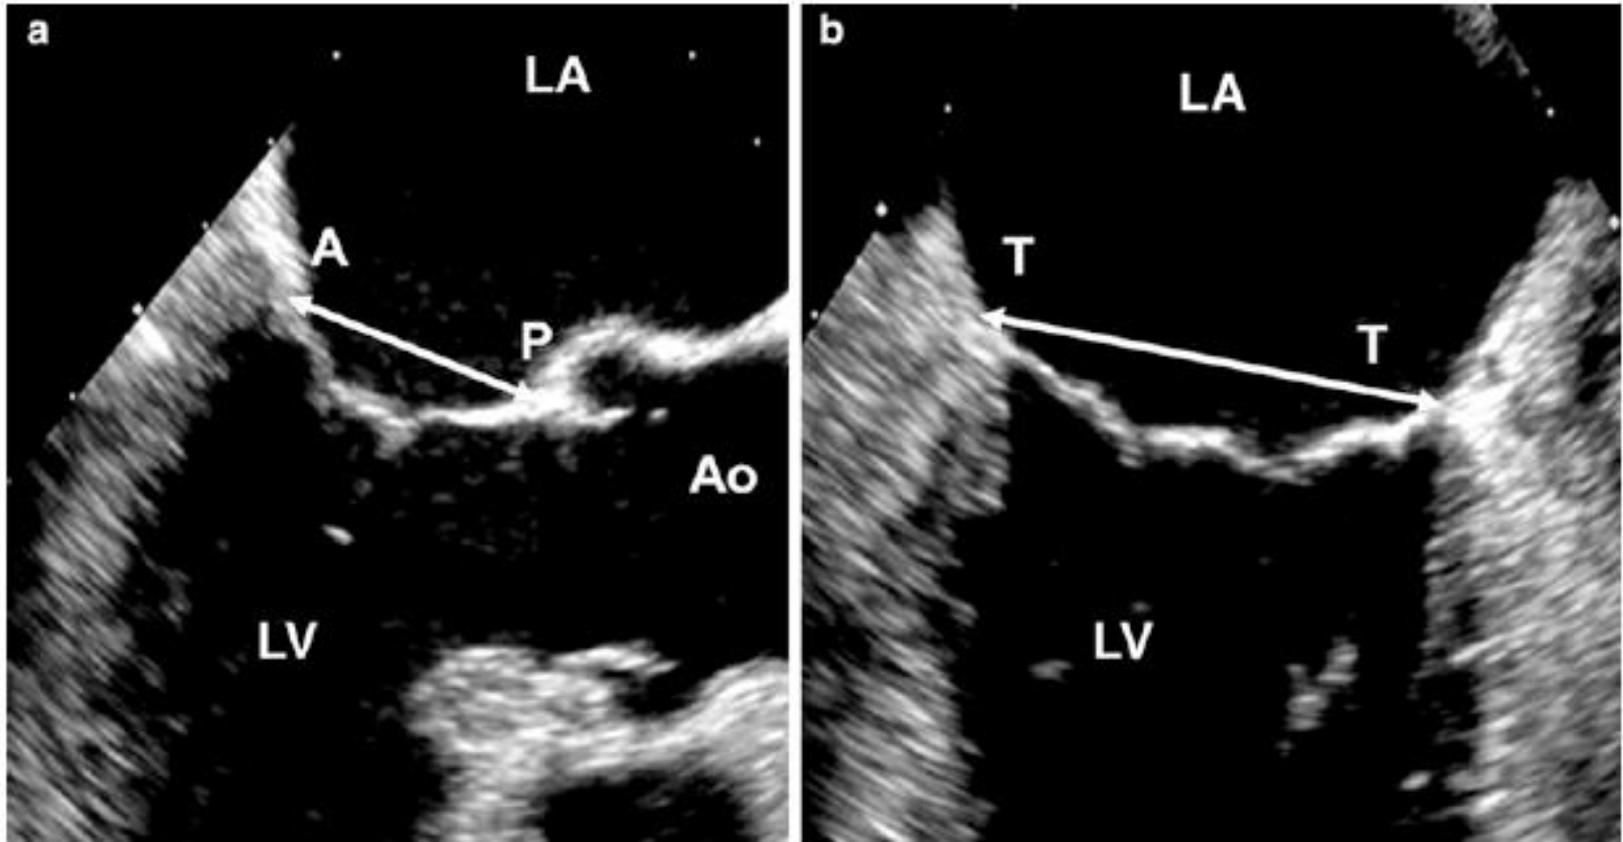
The anteroposterior (*AP*) and transversal (*TT*) diameters measured in (a) the long-axis and (b) two-chamber transesophageal approach. *LA* left atrium, *LV* left ventricle, *Ao* aorta
